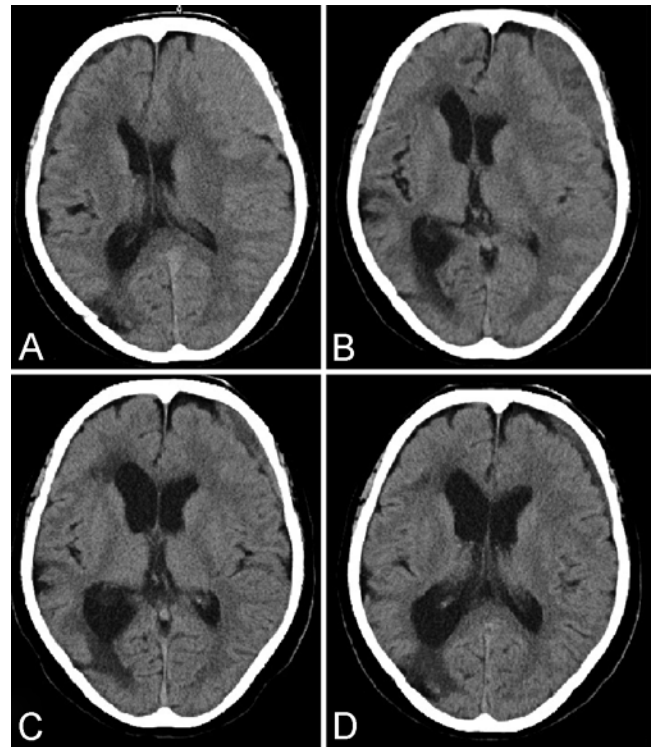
Case 19. CT images obtained after starting tranexamic acid therapy. A: Day 1. B: Day 28. C: Day 78. D: Day 127.
